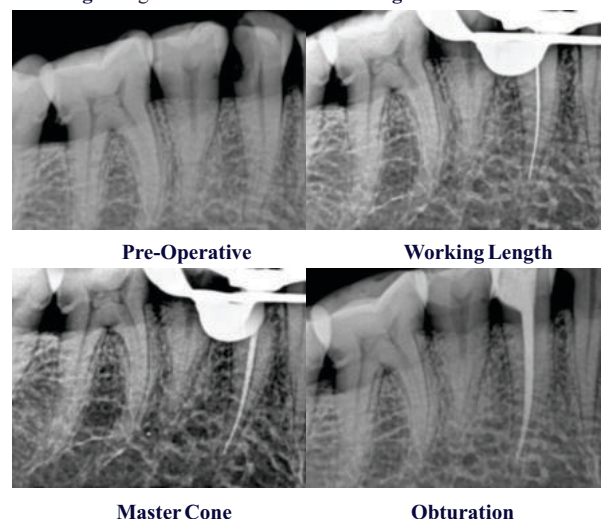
Radiographic Representation Of Single Visit Root Canal Treatment
